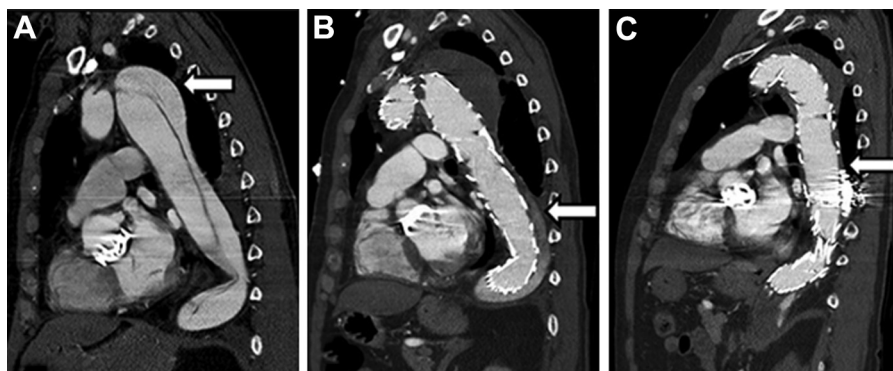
Sagittal CTA showing the type B aortic dissection. (A) Initial CTA on presentation showing the aortic dissection starting just distal to left subclavian artery with a 5.2-cm dilated thoracic aorta (*arrow*). (B) CTA showing further dilatation of the thoracic aorta to
